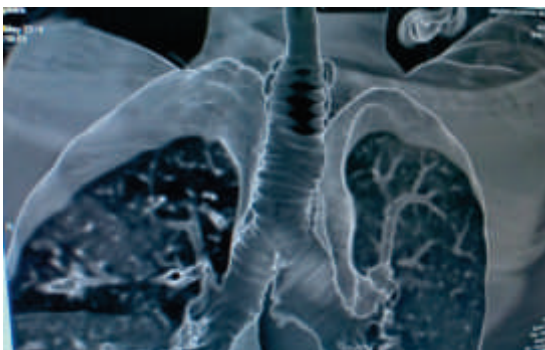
CT thorax with MPR shows abnormally dilated trachea and mainstem bronchi
